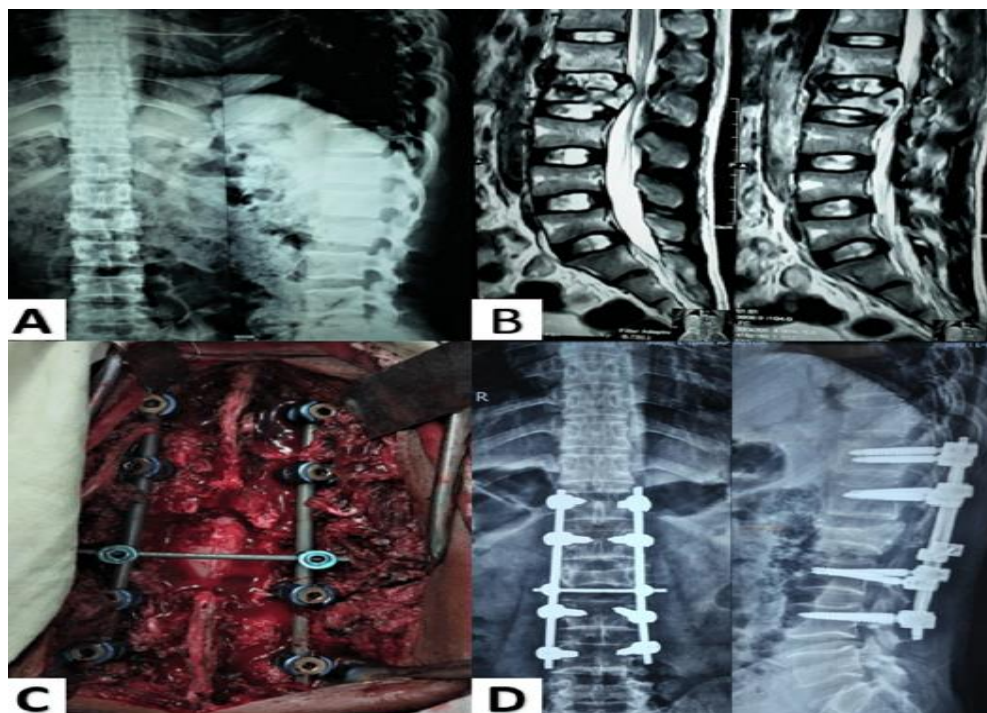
LONG SEGMENT FIXATION OF L2 FRACTURE (A) PRE-OP X-RAYS (B) PRE-OP MRI (C) INTRA-OP PICTURE OF INSTRUMENTATION (D) POST-OP X-RAYS.(10)
